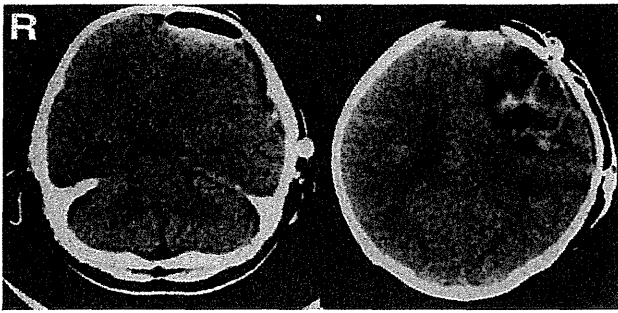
Case 2. Postoperative computed tomography scans showing evacuation of the hematoma.
